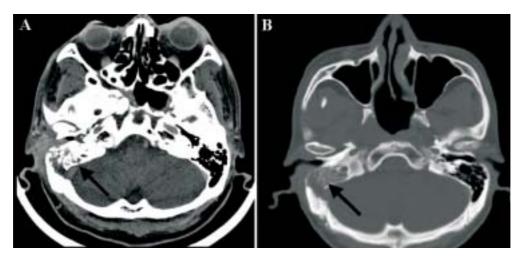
CT of temporal bone (\mathbf{A}); bone window setting (\mathbf{B}). A soft tissue lesion was noted over the right side mastoid region with bony destruction (arrow) and bony cortex disruption.
